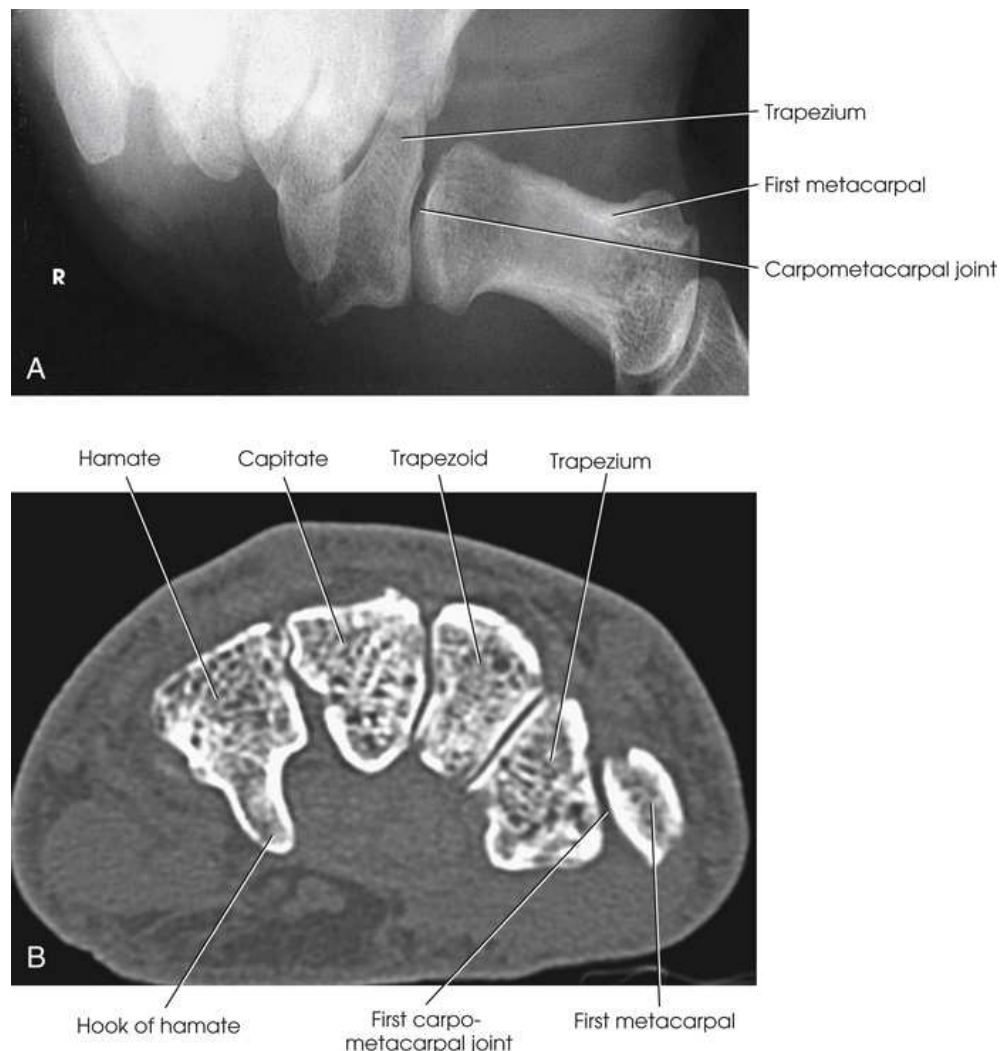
(A) AP thumb to demonstrate the first CMC joint: Burman method. (B) Axial CT scan through distal carpals. Note that CMC joint is well visualized. A, Courtesy Michael Burman.
